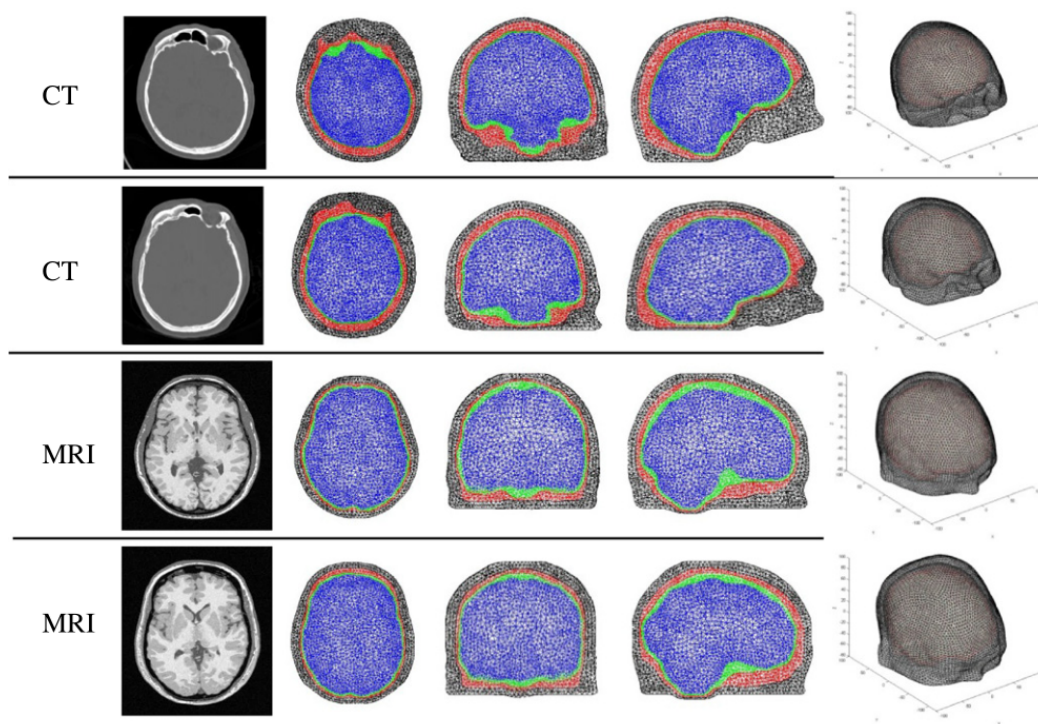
Meshes generated from either CT or MRI scan - Meshes created by Vonach et al. (2012) by either morphing a brain template model into a skull segmented from a CT scan or by estimating the skull shape from an MRI scan.
